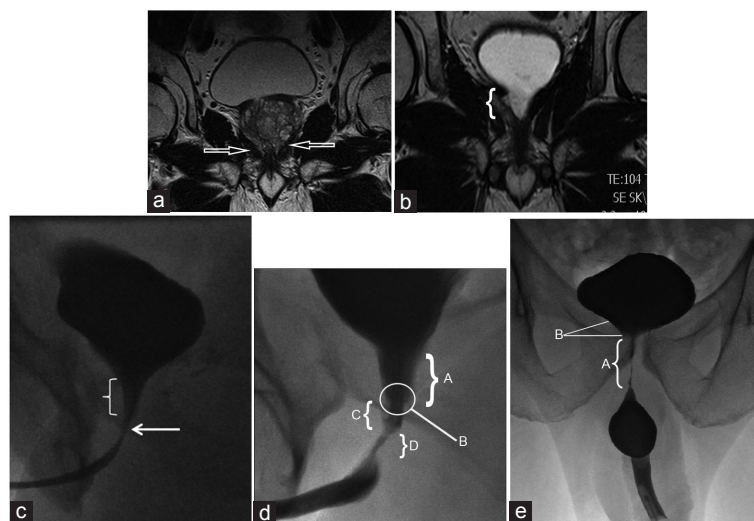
(a) Preoperative MRI – flat and well-supported appearance of the bladder base. Well-developed levator sling (arrows). (b) Postprostatectomy MRI – typical tapered, funneled appearance of the bladder neck. (c) Typical fluoroscopic appearance of a funneled bladder neck after RP with the vesicourethral anastomosis just below it (arrow). (d) Descending urethrogram showing a funneled bladder neck (A) which is contracted and rigid down to the anastomosis (B) and across into the membranous urethra (C) and the proximal part of the urethral sphincter (D). (e) Funneling of the bladder neck not so prominent because the entire funnel is obliterated by the fibrosis giving rise to an extensive contracture (A). Close examination actually shows the proximal end of the funnel terminating abruptly at the proximal end of the contracture (B). RP: radical prostatectomy; MRI: magnetic resonance imaging.
